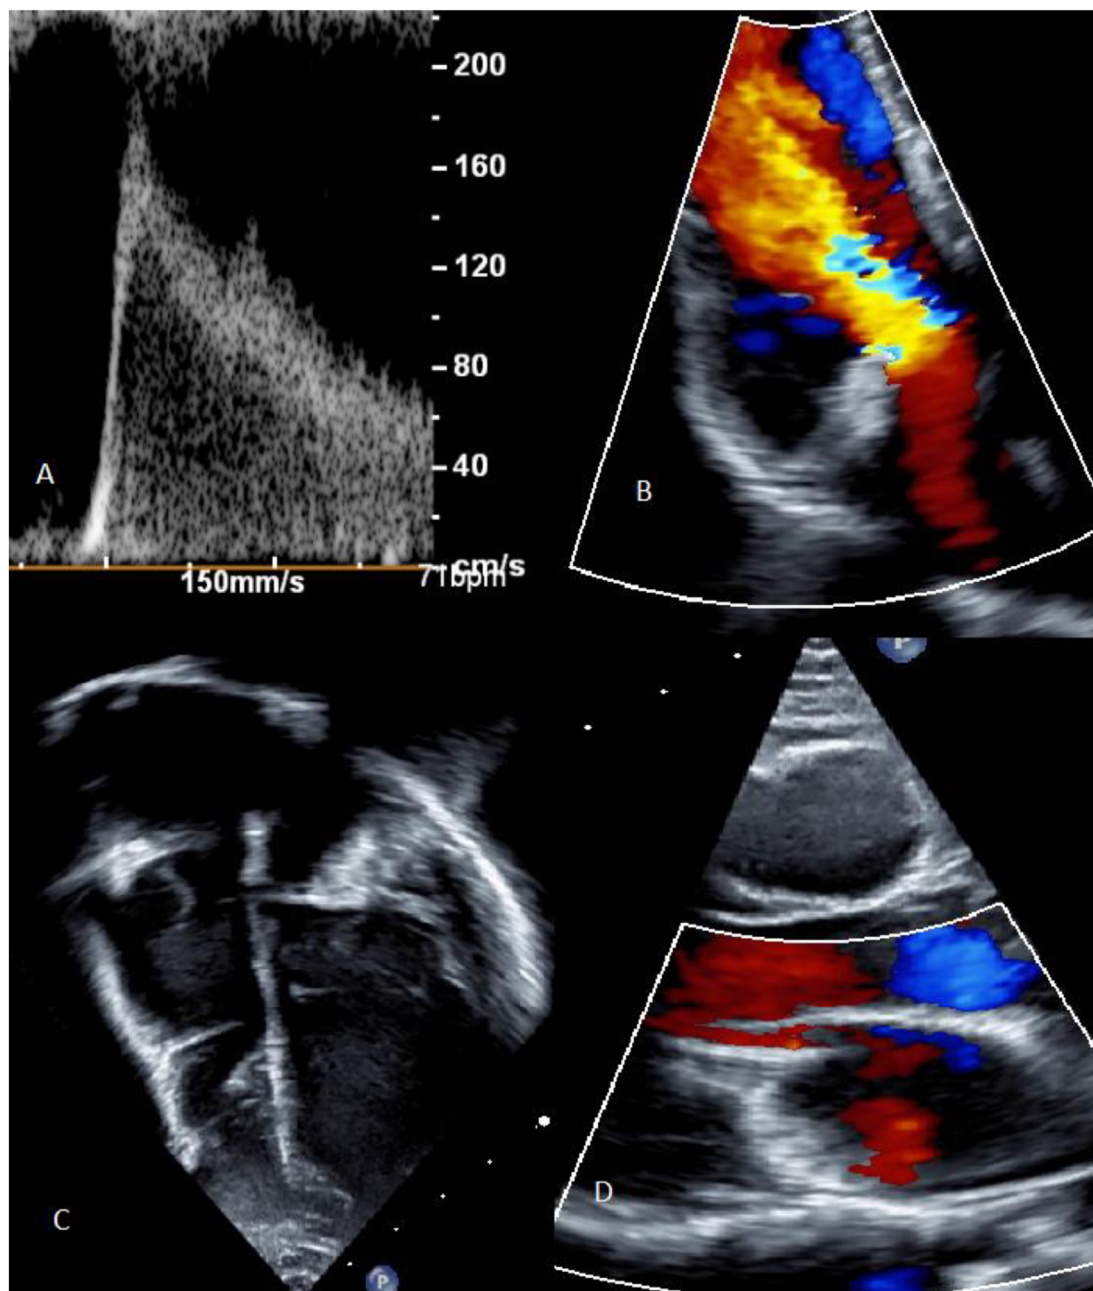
A) Pulse Wave Doppler with increased velocity noted in mitral E wave (1.9 m/s). B) 3 chamber colour Doppler with evidence of turbulence at mitral inflow. C) 4 chamber 2D image with evidence of epicardial lead causing left AV valve stenosis. D) Long axis parasternal colour image with mitral valve stenosis noted.
